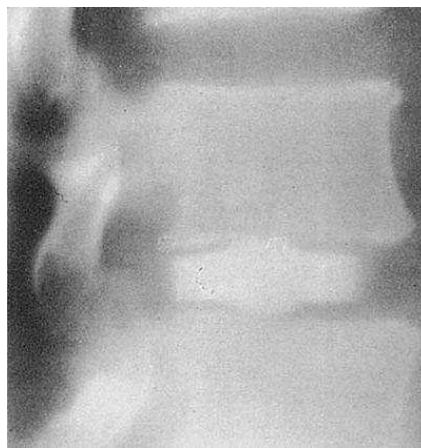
An x-ray of a Fassio device [12]
